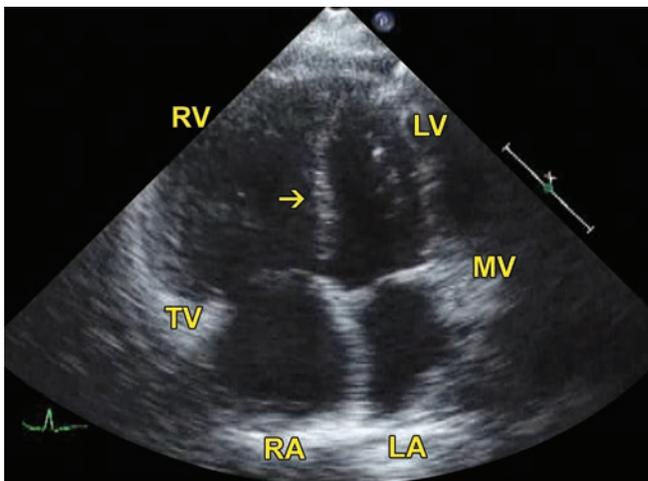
Transthoracic apical 4 chamber view. Arrow points to interventricular septal flattening during systole and diastole. RV is significantly dilated.
